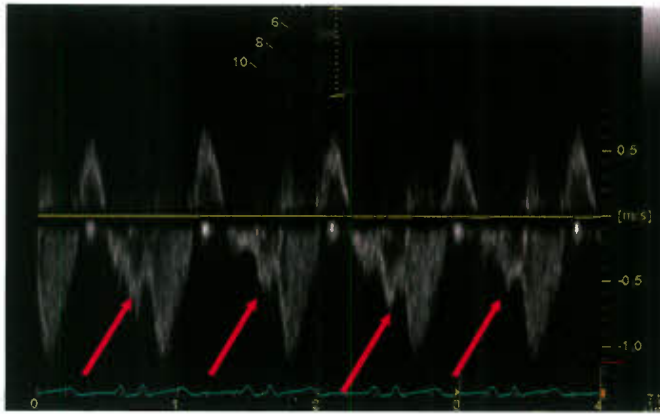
Restrictive RV physiology in a patient after tetralogy of Fallot repair. Pulsed-wave Doppler tracing obtained at the level of the pulmonary valve. This patient had severe pulmonary regurgitation as indicated by the short pressure half-time and only early diastolic flow reversal. During atrial contraction antegrade flow across the pulmonary valve can be recorded (arrows). This suggests that RV end-diastolic pressure during atrial contraction exceeds pulmonary diastolic pressure, which is consistent with restrictive RV physiology.
